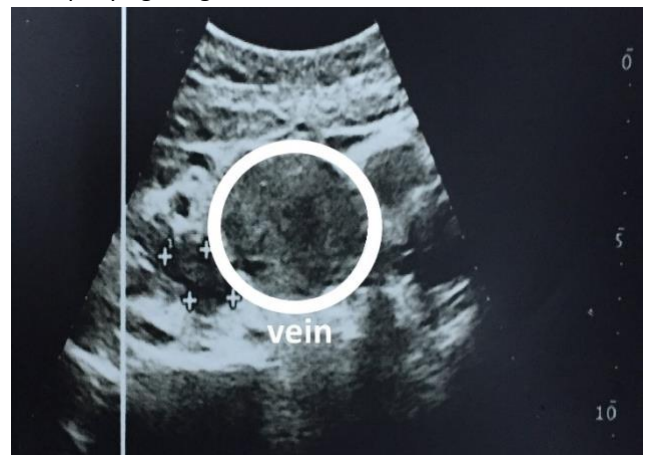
Doppler USG; Thrombus Image in The Right Femoral Vein
